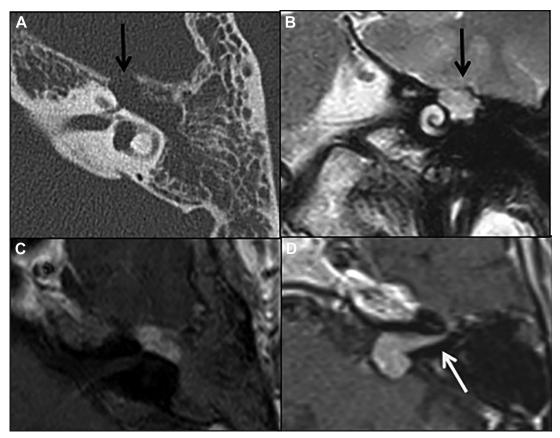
Facial schwannoma (*arrow*) with widening of the GG and extension into the middle ear (*A*). The coronal T2-weighted imaging (WI) (*B*) and the axial postcontrast T1WI (*C*) show expansile, homogeneous, and avidly enhancing lesion centered at the GG. In another patient (*D*), an IAC mass extending to the facial canal (*arrow*), suggestive of a facial schwannoma.
